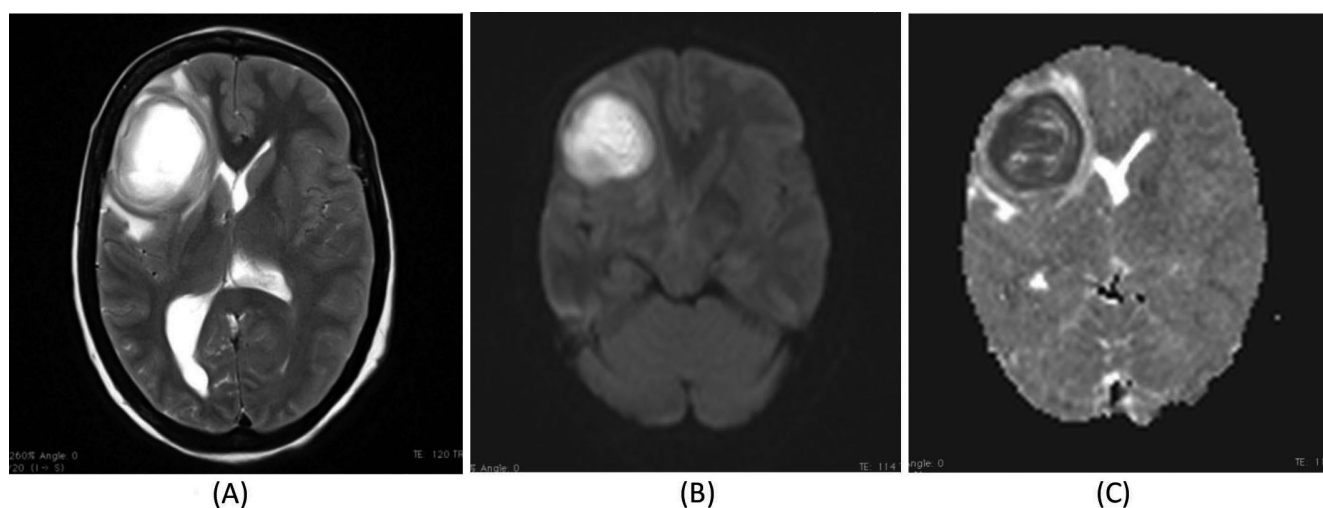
Axial T2W image of right frontal lobe abscess appearing hyperintense with hypointense rim and extensive perilesional edema (A), appearing bright on DWI (B), dark on ADC (C).
